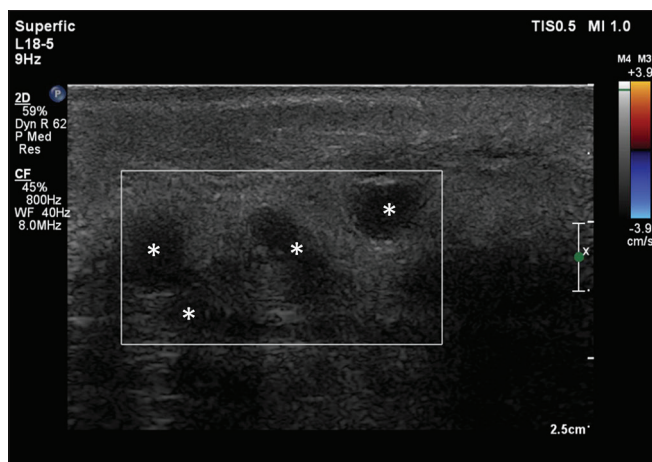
12-year-old child with juvenile recurrent parotitis. Ultrasound image with Doppler showing multiple round hypoechoic areas (*) without any Doppler signal representing multifocal sialectasia
